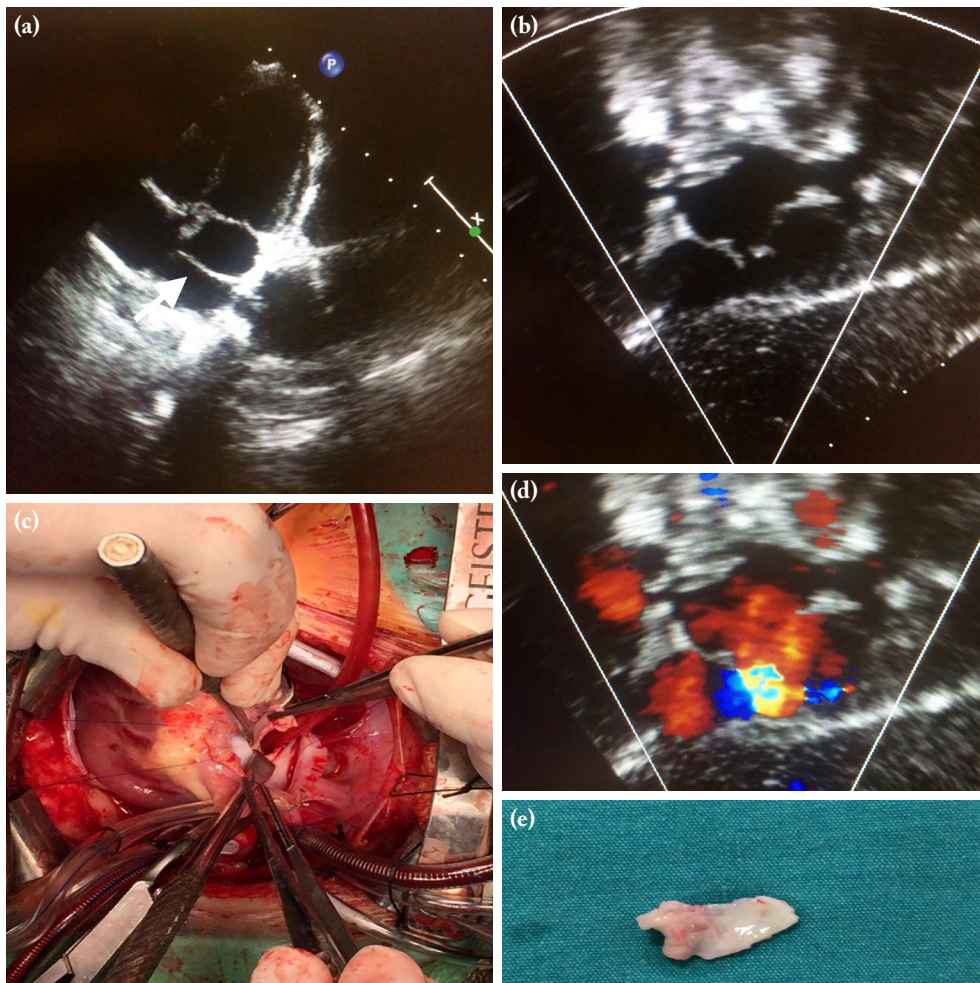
(a, b, d) Echocardiographic and (c) intraoperative images of cor triatriatum sinistrum and (e) image of membrane resected.
